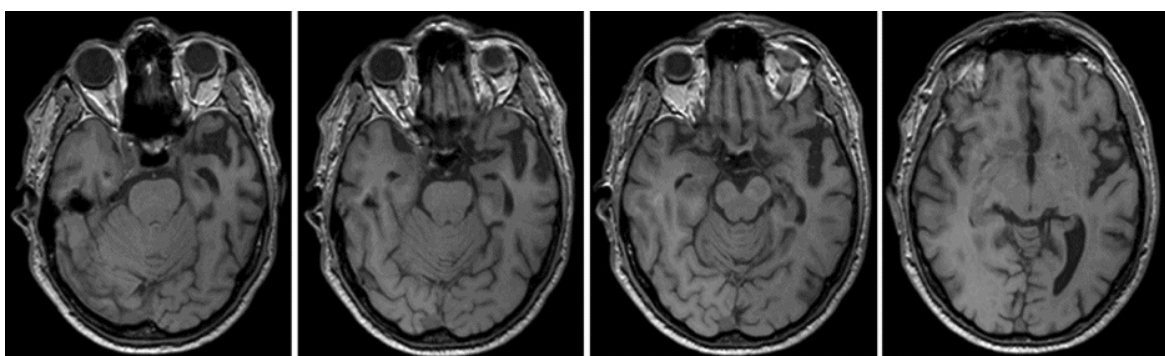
Axial T1-weighted MRI images showing a severe left temporopolar atrophy in a 58-year-old man affected by svPPA. Images are in radiologic convention (i.e., left = right; right = left).
